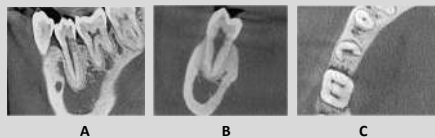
(A, B, C): CBCT examination of the second right lower premolar after 4 years of follow up. A-sagittal view; B-coronal view; C-axial view.
